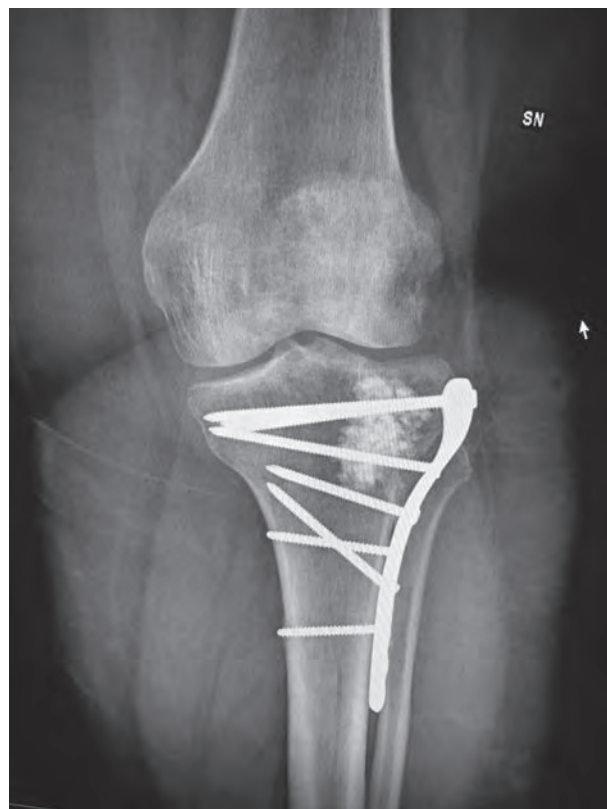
Post-operative radiography at 2 months
